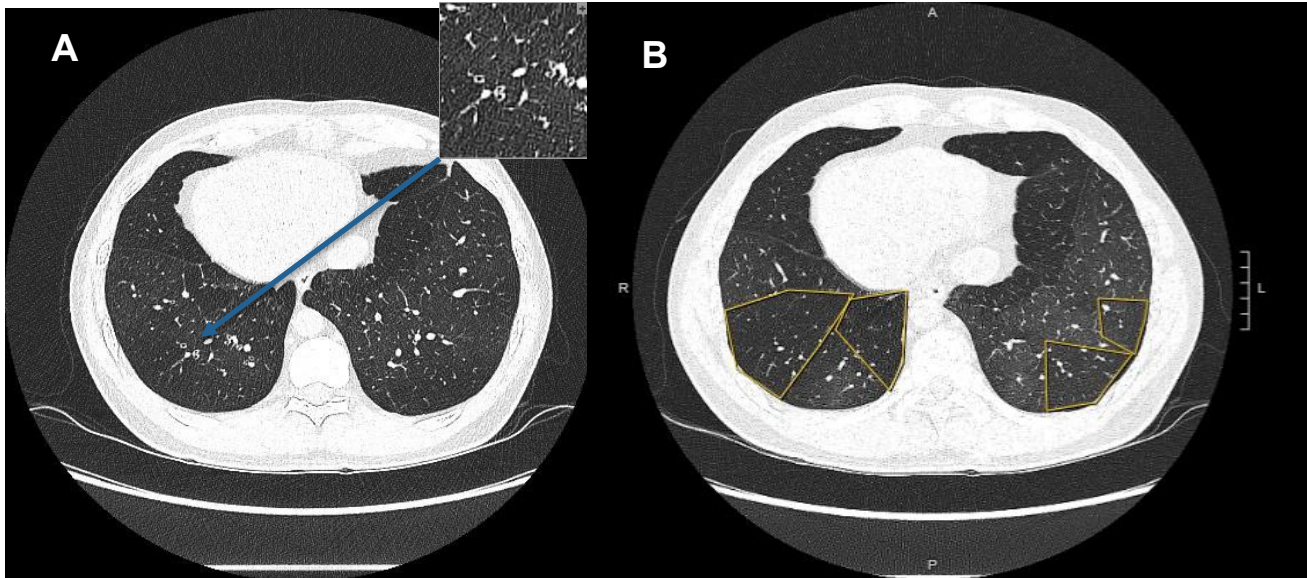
Patient J HRCT performed January 2024. A). Axial view lung section demonstrating a lack of dilation of the bronchi which can occur with or without bronchial wall thickening (Grenier et al., 2021). B). Supine, expiratory axial view of the lungs, demonstrating presence of mosaic attenuation; indicative of bronchiolitis obliterans and gas trapping.
